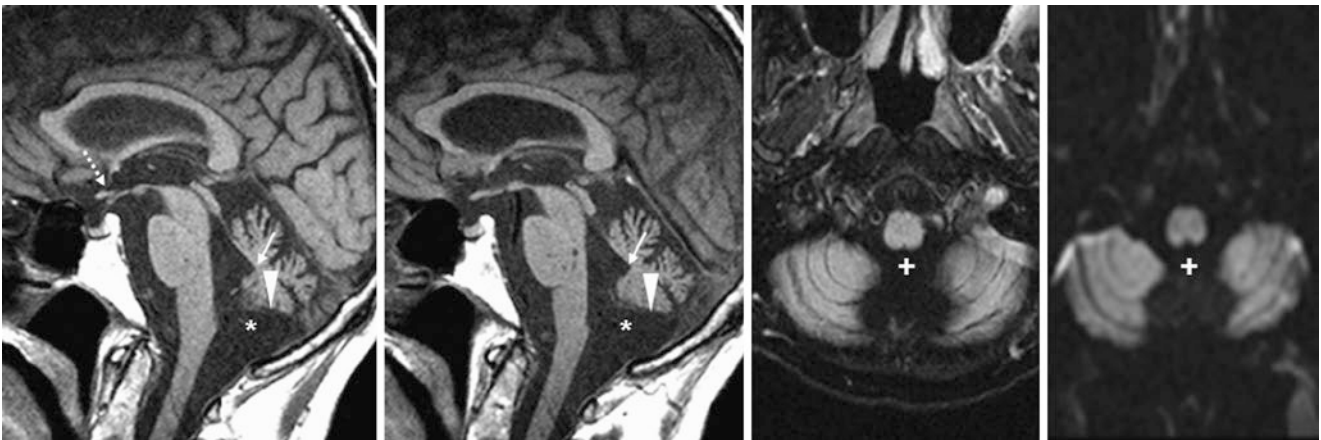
Companion case of BPC. In a 70 year old given an MRI for a stroke work-up (negative), there was a normal size posterior fossa, but with cystic prominence (*) below a normally formed vermis on sagittal T1WI (*left images*), axial FLAIR (*right middle*), and DWI (*right*). The
